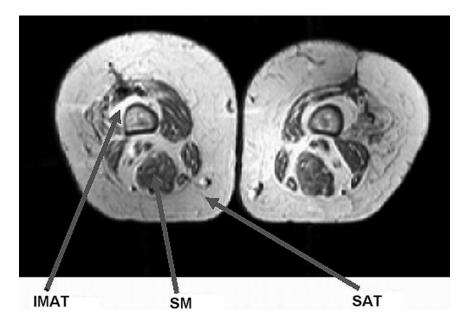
Cross-sectional MRI image from the mid-thigh in a frail obese female participant (76 years of age). *IMAT* intermuscular adipose tissue, *SAT* subcutaneous adipose tissue, *SM* skeletal muscle
